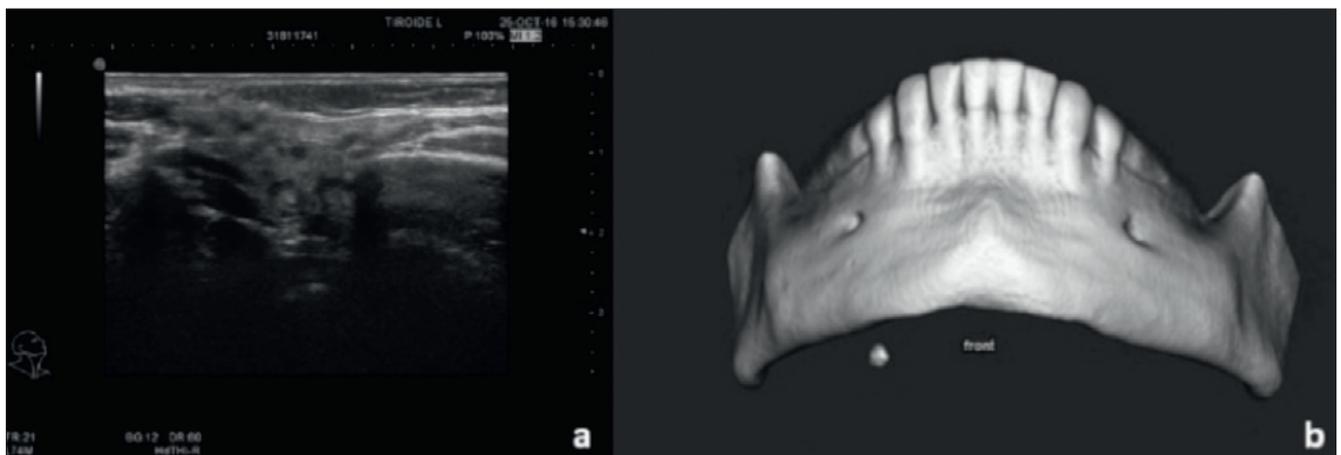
High-resolution US of a patient affected by JRP, showing typical hypoechoic areas and heterogeneous echoes (a); 3D-CBCT image showing a right submandibular stone in a 15-year-old boy.
